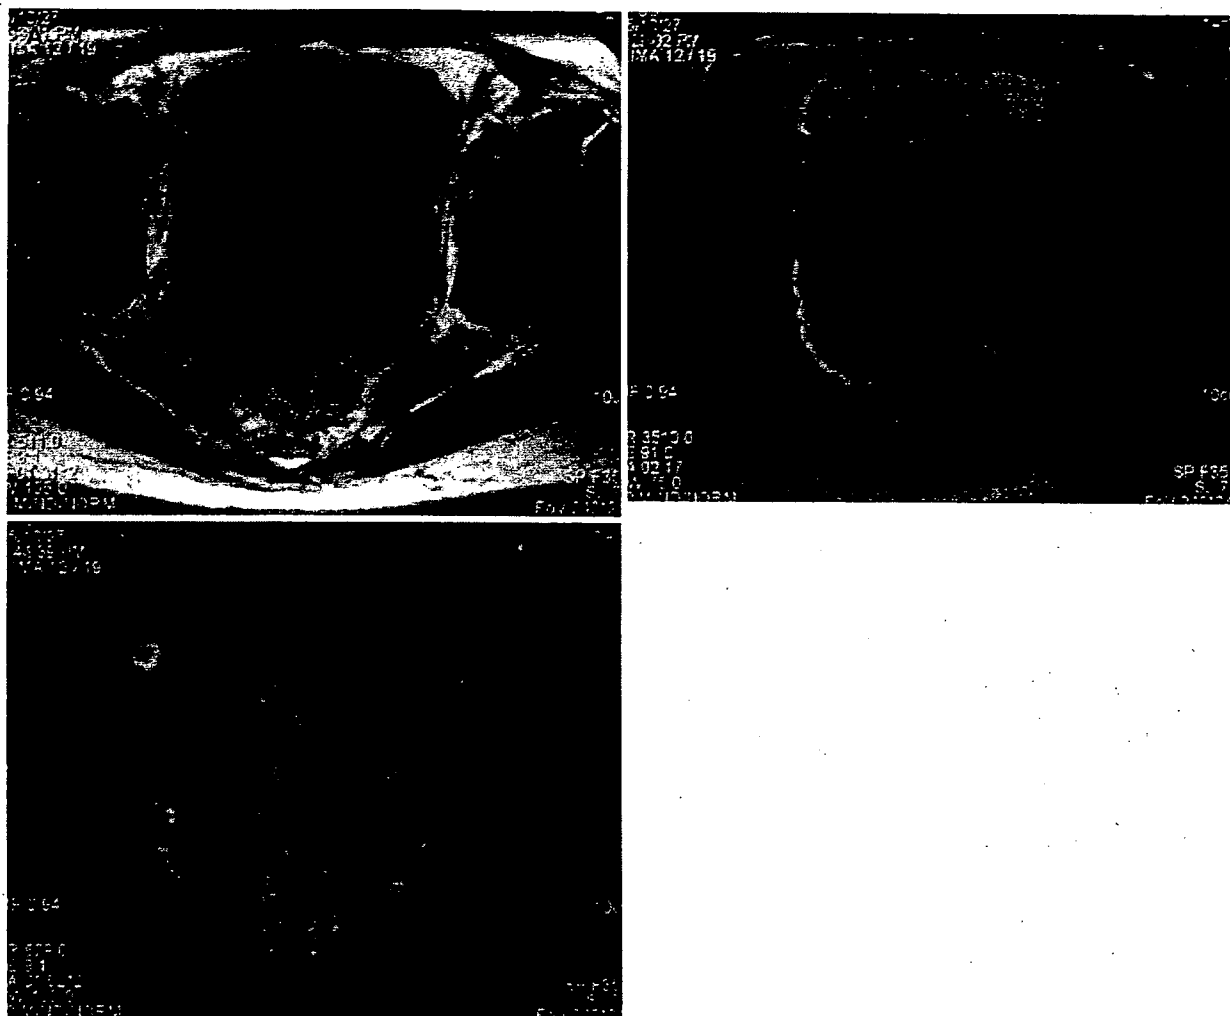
A 53-year-old woman of pT2cN0M0 (grade 3) without endometrioma. A Axial spin-echo T1-weighted MR image (510/9) shows isointense bilateral solid masses (9 cm on the right, 5 cm on the left). B Axial turbo spin-echo T2-weighted MR image (3510/91)
